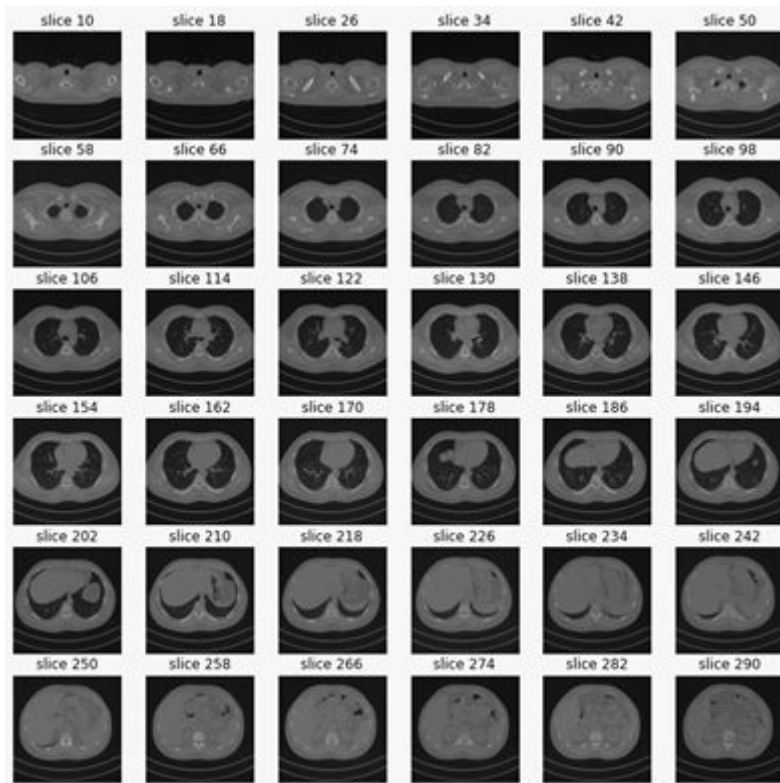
CT Slices before segmentation
